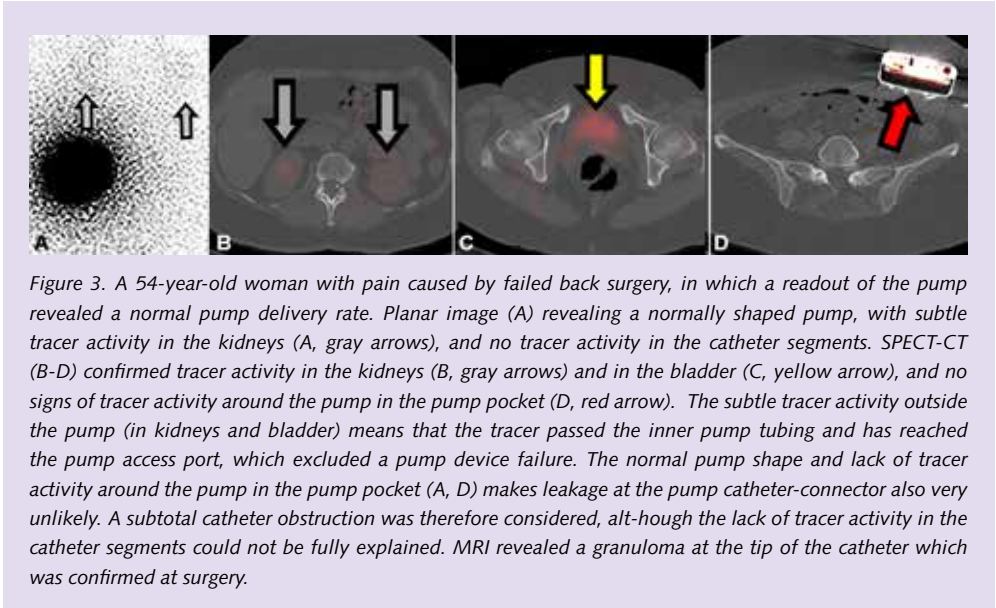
A 54-year-old woman with pain caused by failed back surgery, in which a readout of the pump revealed a normal pump delivery rate. Planar image (A) revealing a normally shaped pump, with subtle tracer activity in the kidneys (A, gray arrows), and no tracer activity in the catheter segments. SPECT-CT (B-D) confirmed tracer activity in the kidneys (B, gray arrows) and in the bladder (C, yellow arrow), and no signs of tracer activity around the pump in the pump pocket (D, red arrow). The subtle tracer activity outside the pump (in kidneys and bladder) means that the tracer passed the inner pump tubing and has reached the pump access port, which excluded a pump device failure. The normal pump shape and lack of tracer activity around the pump in the pump pocket (A, D) makes leakage at the pump catheter-connector also very unlikely. A subtotal catheter obstruction was therefore considered, although the lack of tracer activity in the catheter segments could not be fully explained. MRI revealed a granuloma at the tip of the catheter which was confirmed at surgery.
